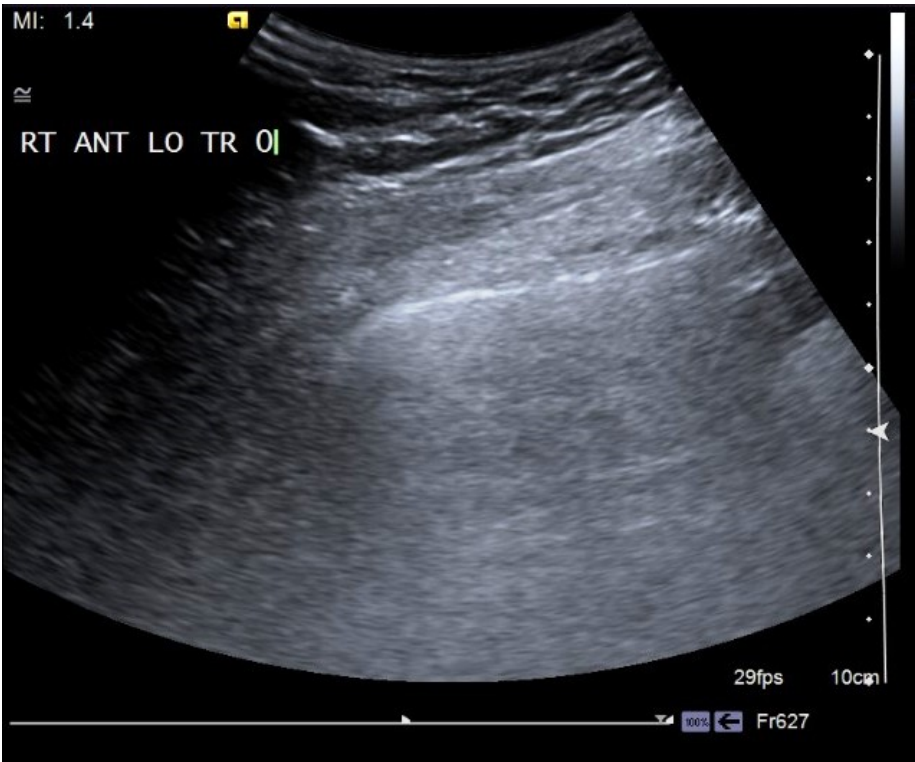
a – Sonographic image of normal lung
